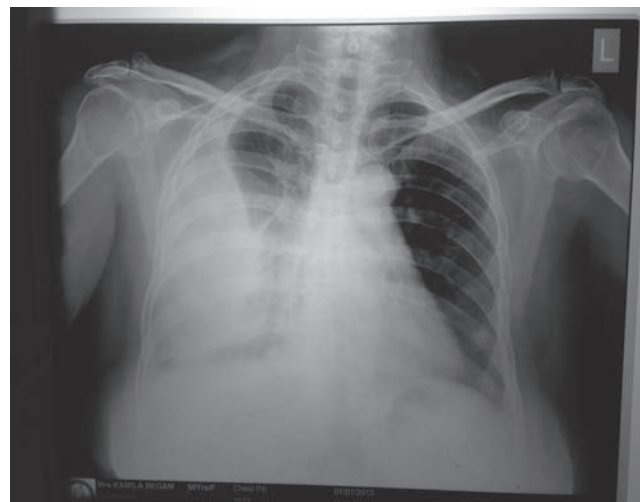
X-ray chest showing right-sided pleural effusion.
